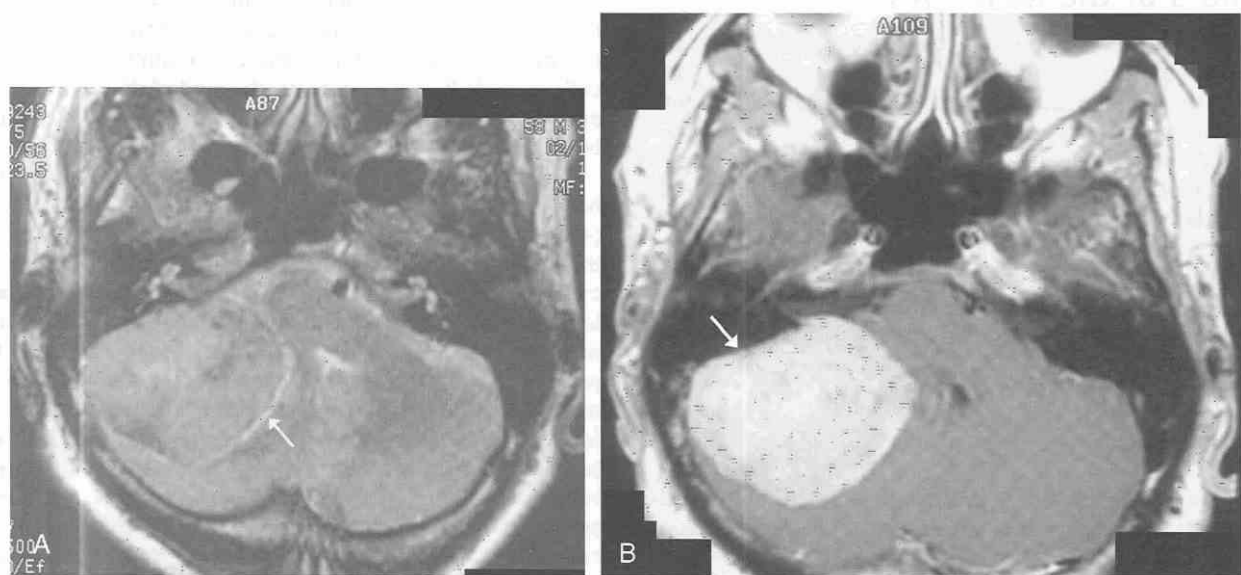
Meningioma arising from the posterior aspect of the left temporal bone. A, Axial T2-weighted MR image demonstrates a large rounded extraaxial tumor mass in the right side of the posterior fossa with its base on the posterior dura of the left temporal bone. The mass is slightly hyperintense relative to gray matter and compresses and displaces the right cerebellar hemisphere posteriorly and medially. A narrow cleft of cerebrospinal fluid (arrow) separates the medial margin of the tumor from the adjacent compressed cerebellum and pons. Note that the internal auditory canals bilaterally are filled with cerebrospinal fluid. B, Following intravenous administration of gadolinium, an axial T1-weighted image demonstrates intense homogeneous contrast enhancement of this large dural-based tumor (arrow).
